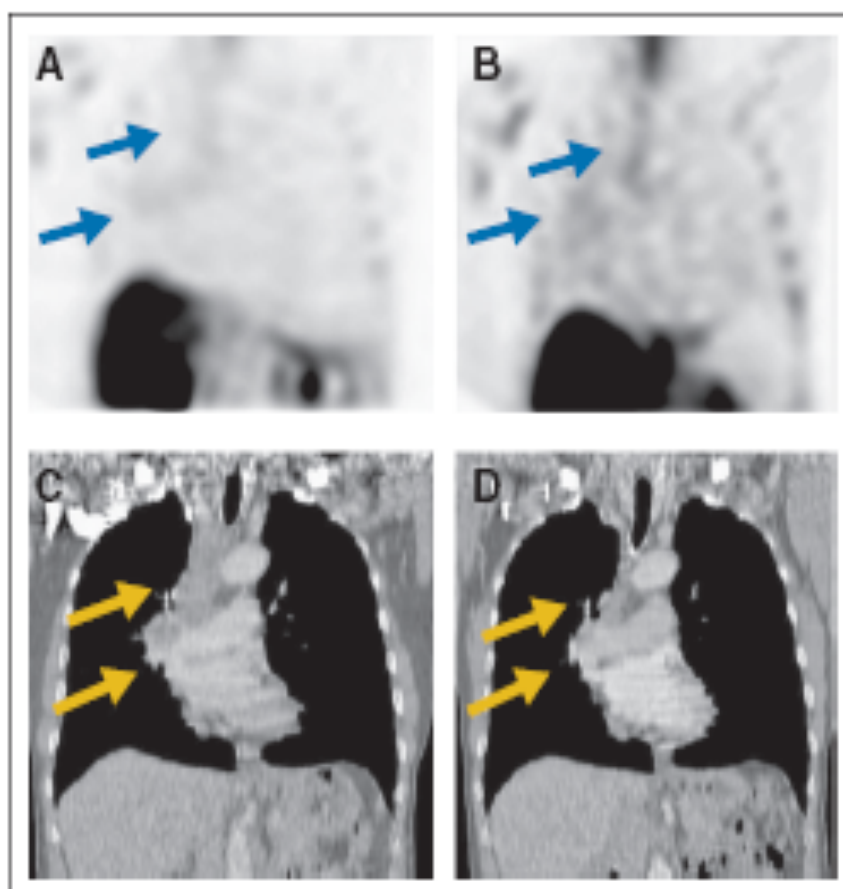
(A) Baseline and (B) follow-up ^{99m}Tc -Hynic-rh-annexin V single-photon emission tomography demonstrate chemotherapy-induced increase of tumor tracer uptake (arrows). (C) Baseline computed tomography demonstrates solid mass in the right upper lobe enlarged mediastinal lymph nodes (arrows). (D) Follow-up computed tomography scan 8 weeks after the start of chemotherapy shows complete response (arrows).
